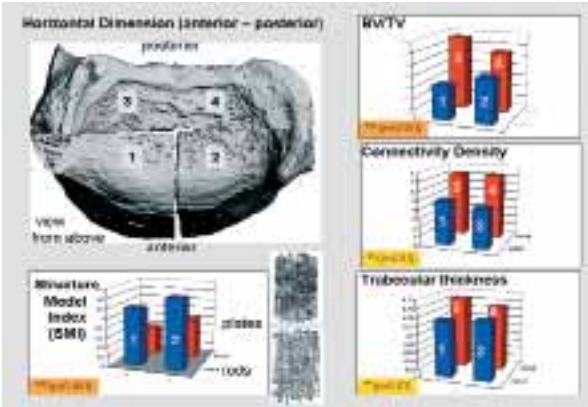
Mikro-CT results in the horizontal dimension
